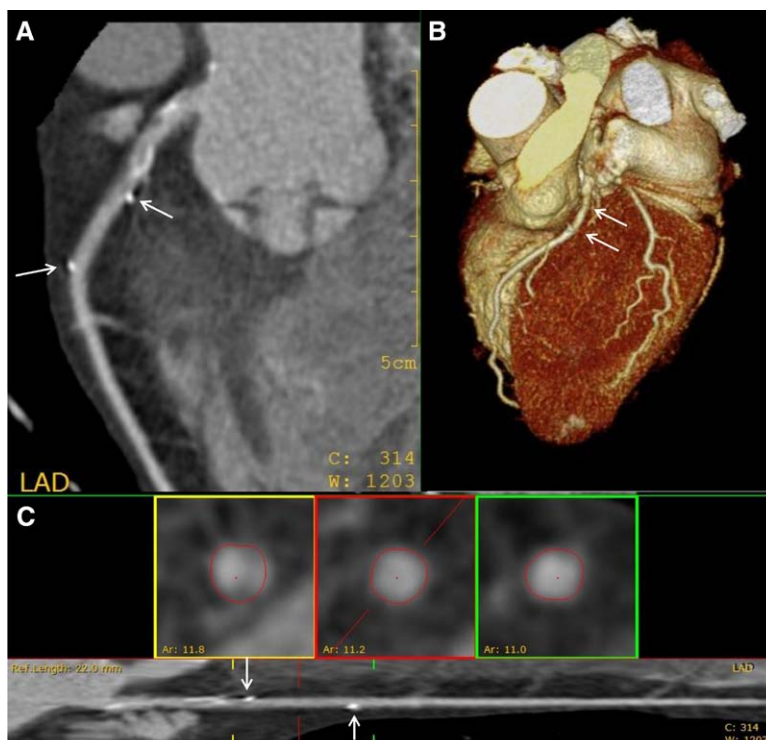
Computed tomographic (CT) angiography of 78-year-old woman treated by bioresorbable vascular scaffold (BVS; 3.5/18 mm) for anterior ST-segment-elevation myocardial infarction (STEMI). At curved multiplanar reconstruction (MPR; A), 3D volume rendering (B), and straight MPR reconstructions (C), proximal and distal markers are clearly identified in left anterior descending (LAD; white arrows). For quantitative assessment (C), proximal and distal reference cross-sections (yellow and green box) were identified for reference area measurement. In-scaffold segment was analyzed using 0.5 mm slice thickness to find a cross-sectional view with minimal lumen area. Area stenosis was 1.7%.
